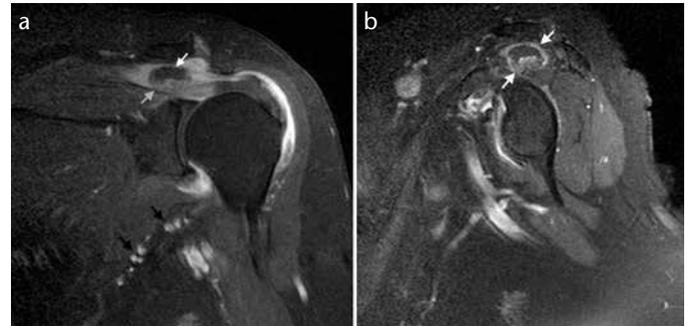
a, b. T1 weighted spir MRI of the left shoulder in coronal (a) and sagittal (b) planes displays a mass showing contrast uptake in supraspinatus muscle (gray arrows) and axillary lymph nodes (black arrows)
